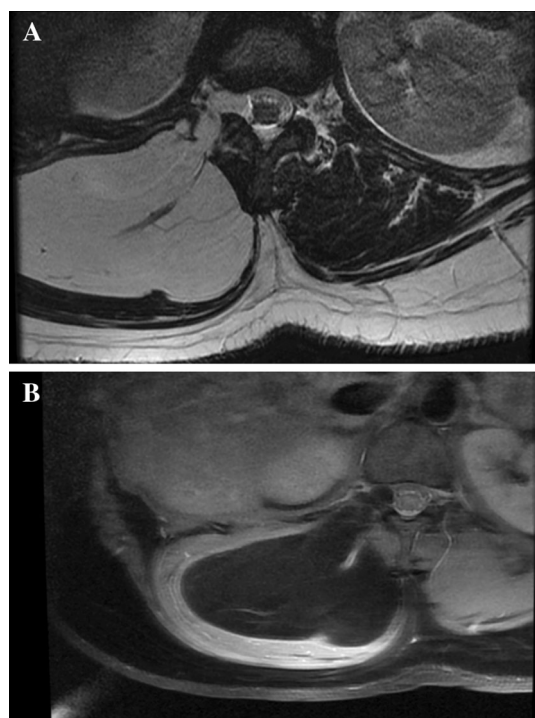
a T1-weighted axial view showing a hyperintense paraspinal lesion with a right T12–L1 foramen. b Enhanced periphery after gadolinium injection
